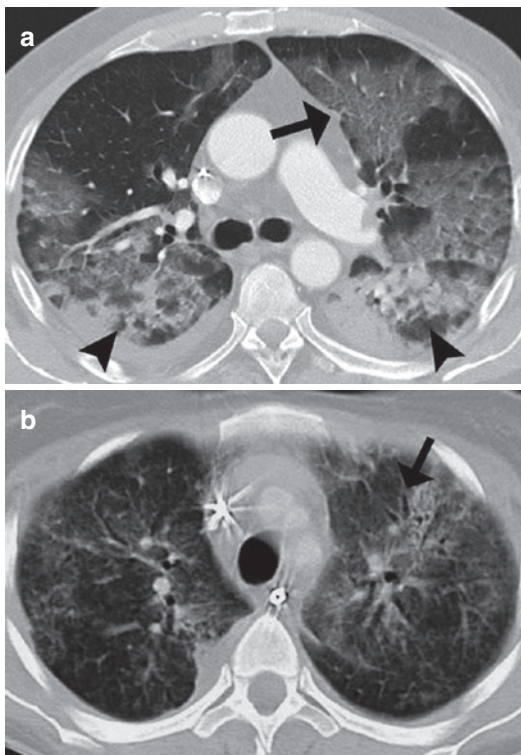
(a, b) Acute interstitial pneumonia (AIP) in a 58-year-old patient. Axial CT image shows bilateral ground-glass opacities in a geographic distribution (arrow). Consolidation is seen in the more dependent lung (arrowheads). Small coexisting bilateral pleural effusions are present (a). Fibrotic changes with traction bronchiectasis (arrow) and architectural distortion in the late phase of acute AIP (b)
